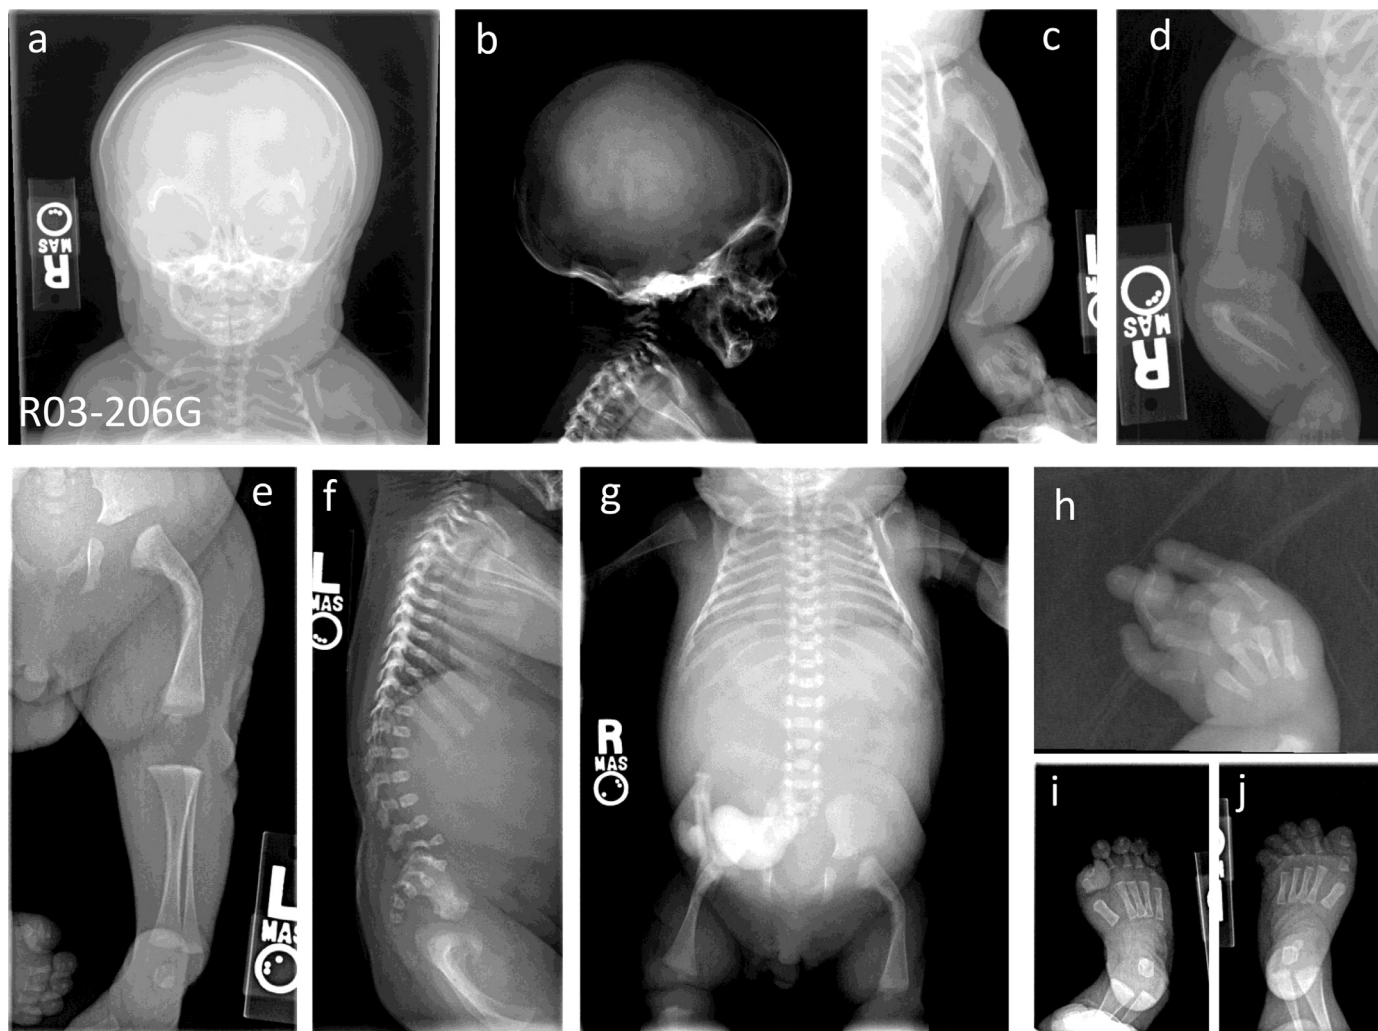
Radiographic findings in R03–206 G. Full term fetus with enlarged skull (a), micrognathia (b), presence of scapula and elbow dislocations (c), slight bowing of the humerus, radius and ulna (c, d), severely bent femurs with cortical abnormalities (e), platyspondyly with coronal clefts (f), aplastic acetabular roofs (g) ulnar deviation and contractures in the hands (h) and bilateral equinovarus (i, j).
